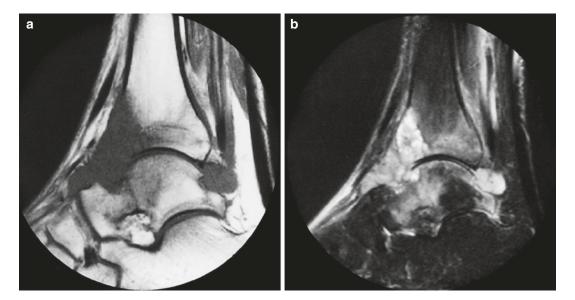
Synovial sarcoma developing within the ankle joint. (a) Sagittal T1-weighted MR image. (b) Sagittal STIR image. A low signal intensity mass is present within the anterior and posterior recess of the ankle joint. There is associated erosion of the talar neck. The anterior cortex of the distal tibia is destroyed. Bone marrow edema is seen
